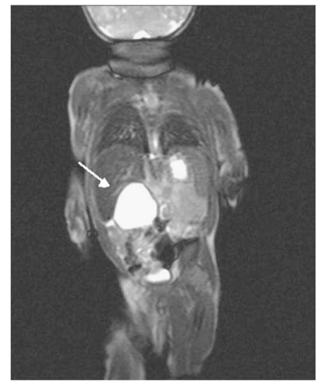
Magnetic resonance imaging with evidence of iron deposition in the liver. Liver measures 5.3 cm in height. There is no intrahepatic duct dilatation. The liver iron concentration is read as consistent with moderate to severe iron deposition and was based on the standards established by Yves Gandon at the University of Rennes, France.
